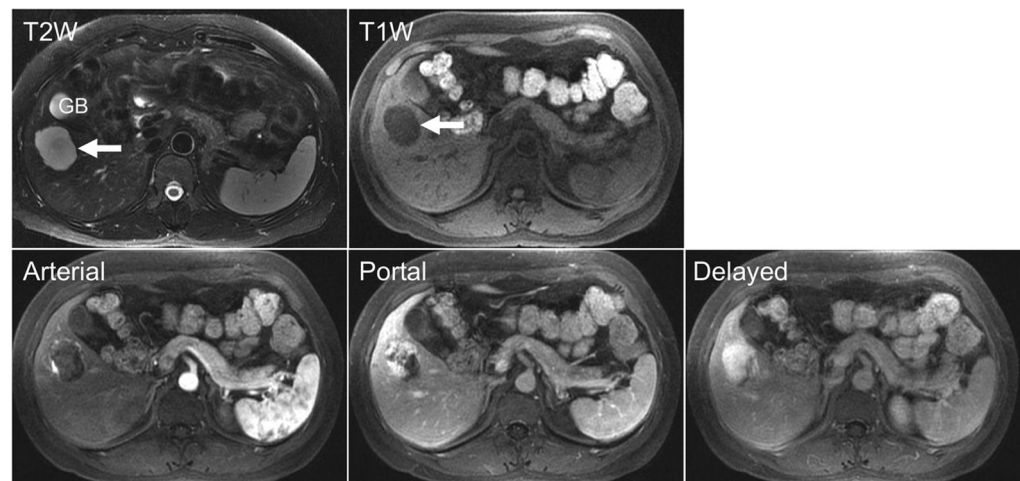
MRI of a cavernous hemangioma of the liver. The hemangioma (arrow) shows a typical bright signal on the T2-weighted image, hypointensity on the T1-weighted image, and peripheral nodular enhancement in the arterial phase with centripetal filling in the portal venous phase and near-complete filling in the delayed phase. GB, gall bladder; T1W, T1-weighted; T2W, T2-weighted.
